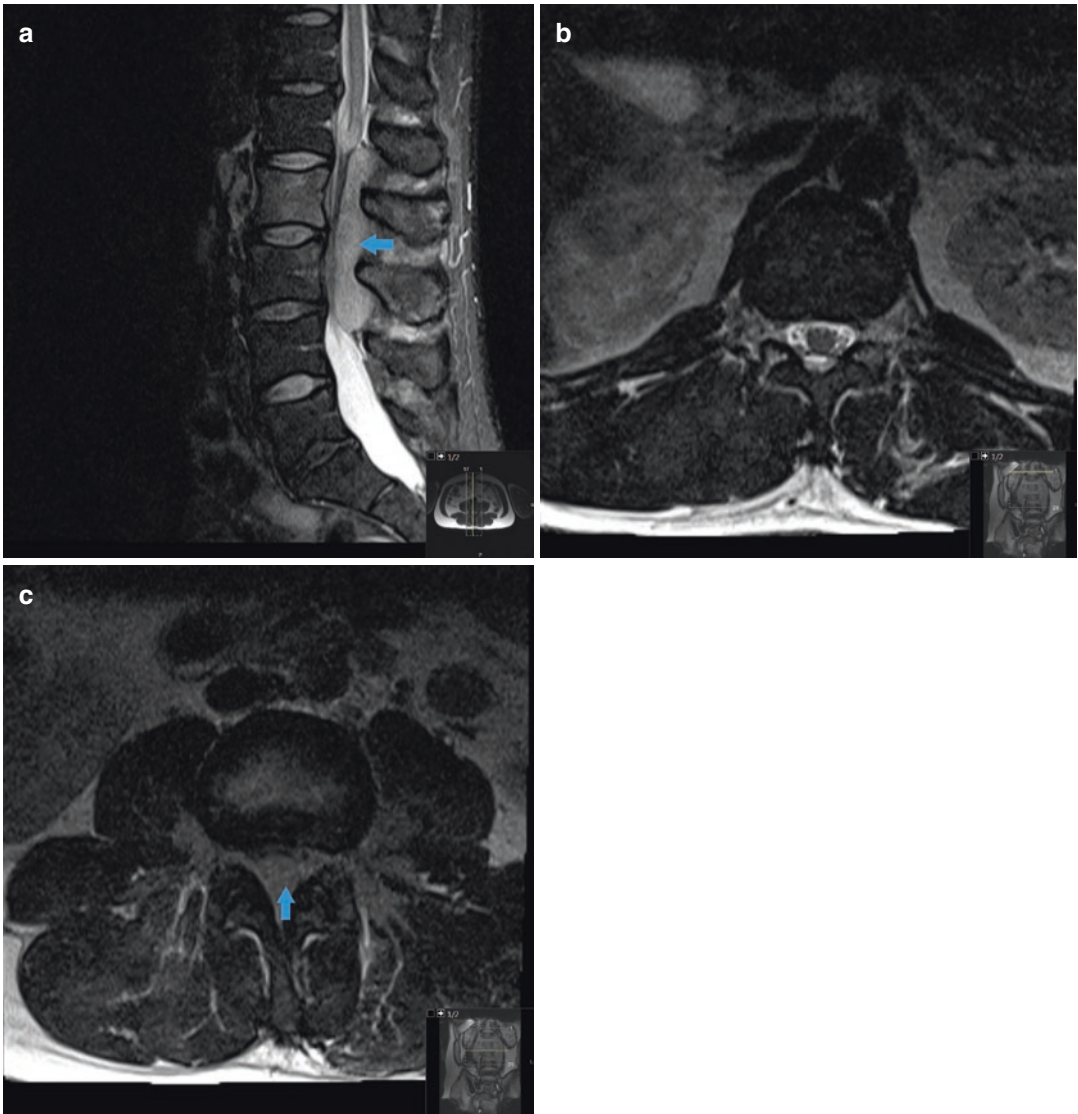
Lymphoma. Figure 9.1a is a sagittal fat-saturated T2-weighted MR image showing a large primarily dorsal epidural soft tissue mass causing marked spinal canal stenosis and compression of the cauda equina (arrow). Figure 9.1b is an axial T2-weighted MR image taken above the level of compression, showing normal appearance of the distal conus medullaris and thecal sac.
